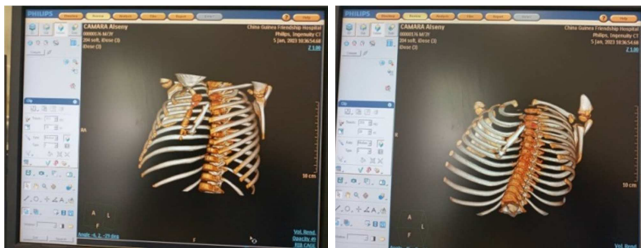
Chest CT showing a longilinear foreign body after a 60° rotation.
